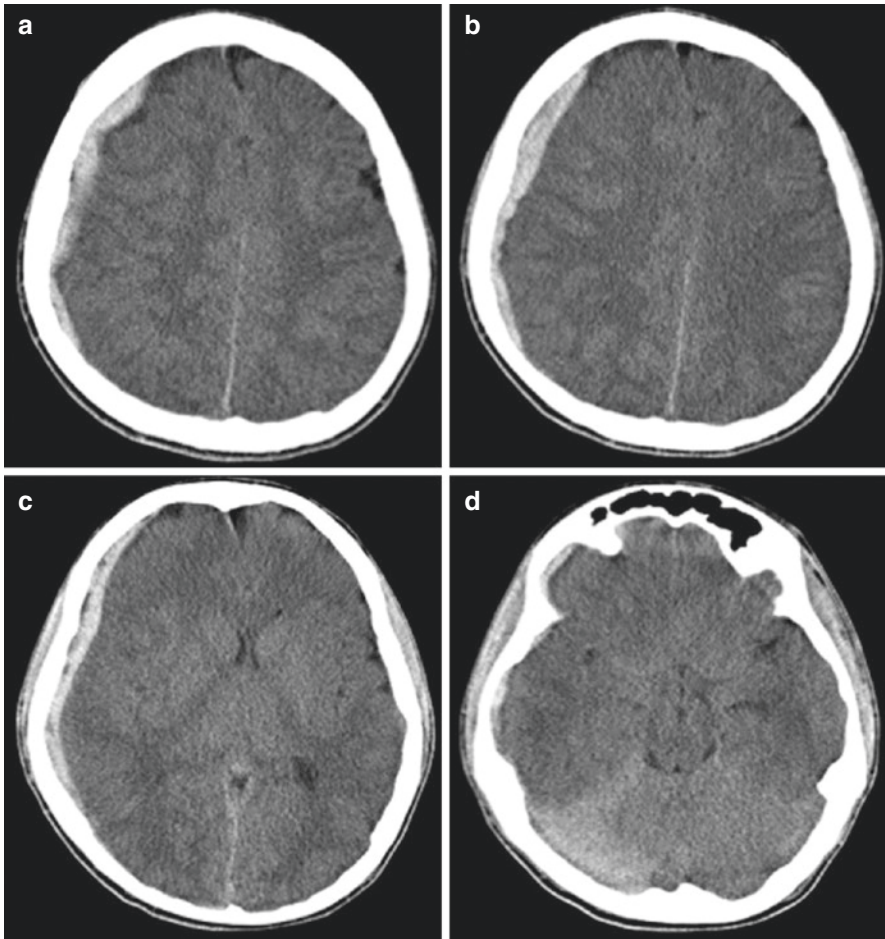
Non-contrast CT of head for SDH SRSBI. (a, b) 9-mm acute right convexity subdural hemorrhage with associated effacement of ipsilateral sulci and midline shift; (c) 8-mm of midline shift related to hemorrhage with significant effacement of lateral ventricles; (d) extension of subdural towards floor of anterior and middle fossa with further layering along right tentorium, early right uncus herniation with effacement of crural cisterns. (With permissions from Yengo-Kahn et al. [49])
